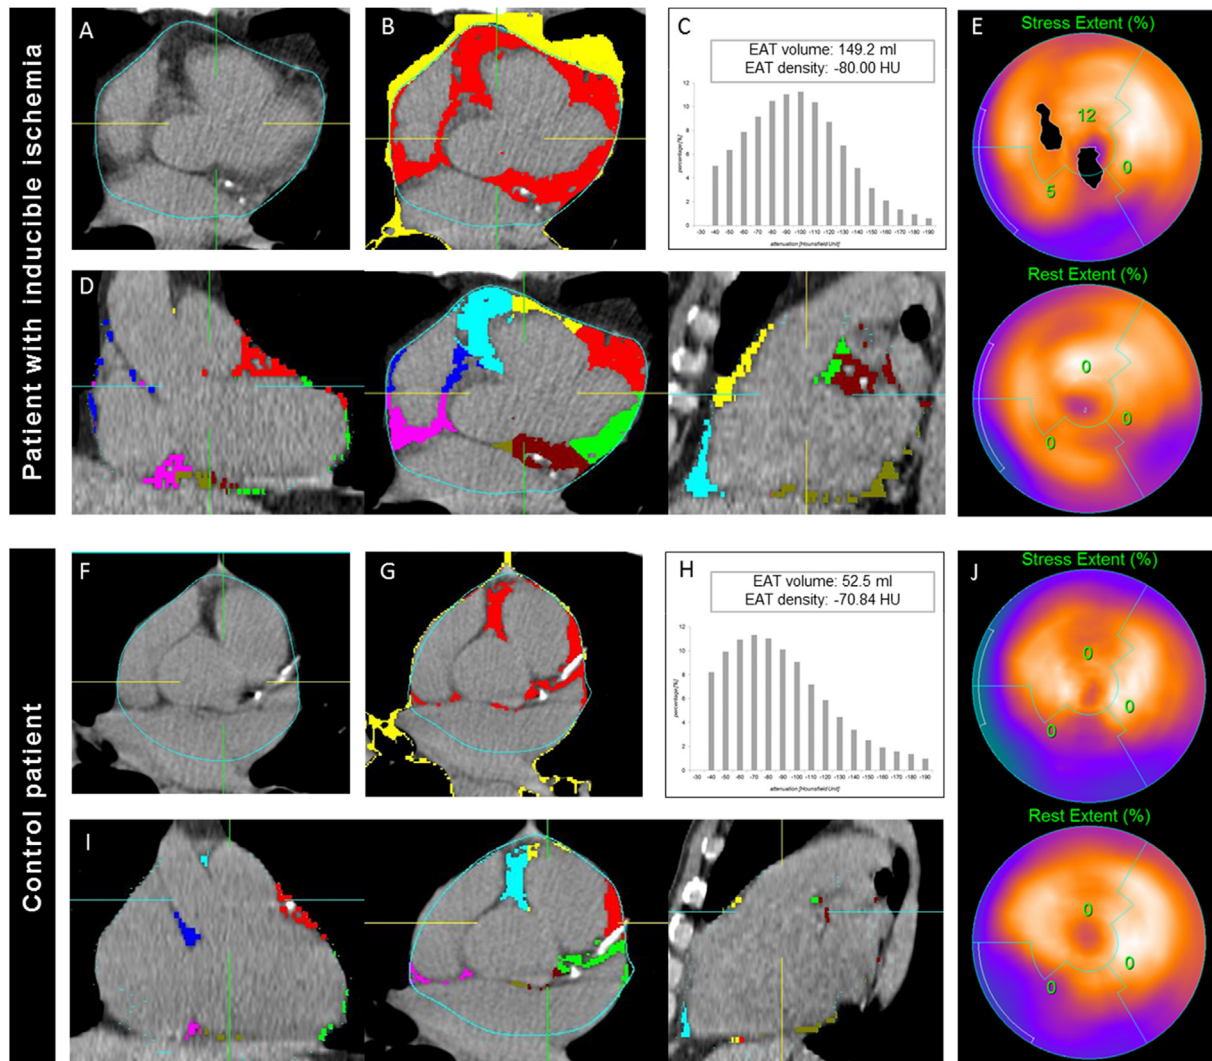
Representative examples of EAT volume and attenuation analysis in a patient with inducible myocardial ischemia and matched control patient. Top panel images are from a 54-year old male patient with inducible myocardial ischemia (SSS 5, SDS 5, CCS 691). Axial slice with automatically generated pericardial contour (A) and detected epicardial adipose tissue (EAT, red filling) and thoracic adipose tissue (TAT, yellow filling) volume (B). (C) shows histogram for total EAT density for the range -190 to -30 HU, global EAT volume is 149.2 ml, mean EAT density is -80.00 HU. (D) presents standard coronal, axial and sagittal views with sector analysis of EAT. (E) presents corresponding SPECT data (top: stress image, bottom: rest image). Bottom images are from a 59-year old male matched control patient (SSS 0, SDS 0, CCS 1054). Axial slice with automatically generated pericardial contour (F) and detected EAT (red filling) and TAT volume (yellow filling) (G). (H) shows histogram for total EAT density for the range -190 to -30 HU with a definite left shift compared to histogram from patient with inducible myocardial ischemia. Global EAT volume is 52.5 ml, mean EAT density is -70.84 HU. (I) presents standard coronal, axial and sagittal views with sector analysis of EAT. (J) presents corresponding SPECT data (top: stress image, bottom: rest image).
